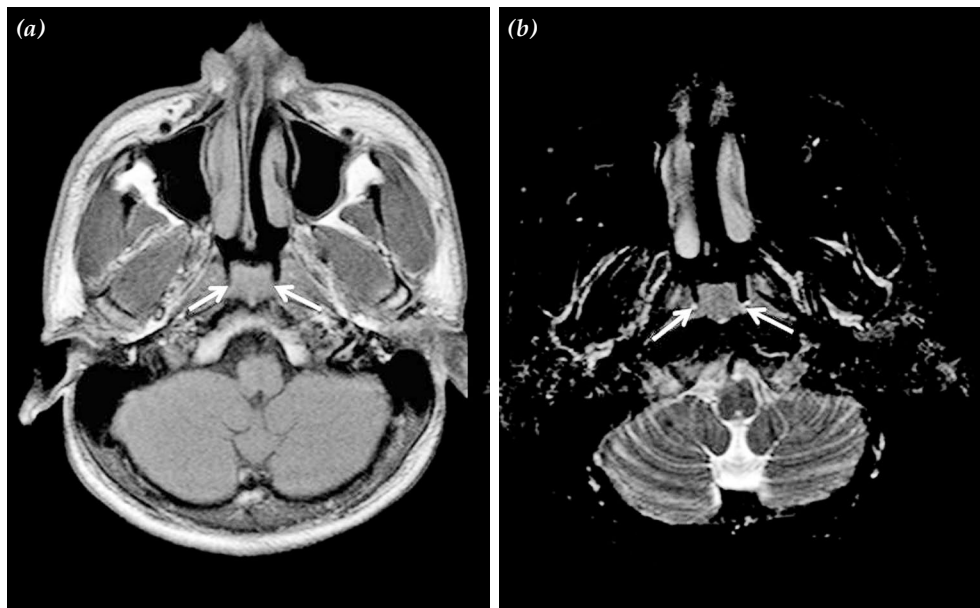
(a) T₁-weighted and (b) T₂-weighted fat saturated magnetic resonance images in the axial plane through the nasopharynx and maxillary sinuses. A homogeneous soft-tissue mass was located on the posterior wall of the nasopharynx and was isointense to adjacent lymphoid tissue (white arrows).
